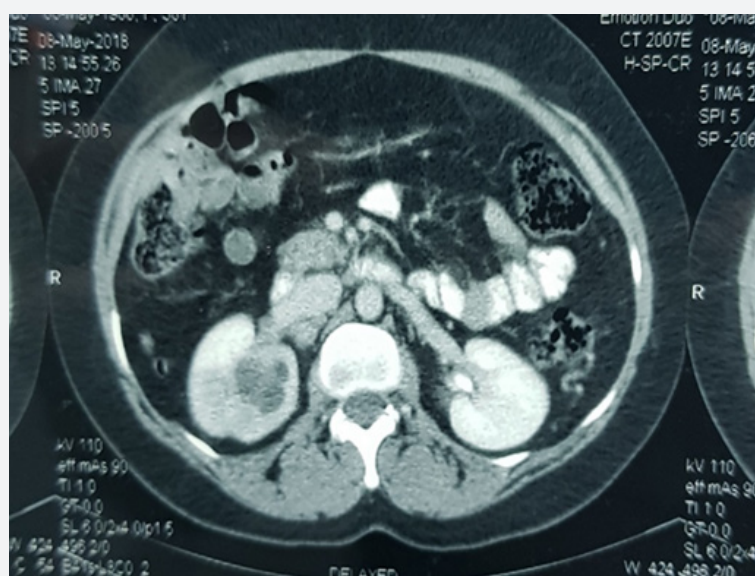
CT: Renal Hydatid with Daughter Cyst.
